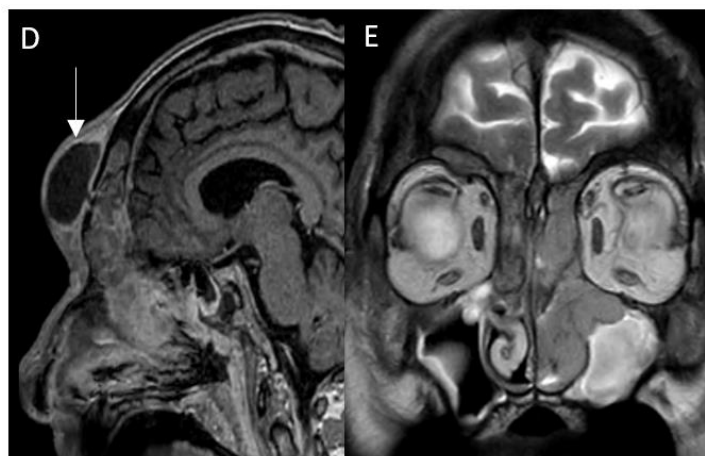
D. Contrast-enhanced MRI of the brain: fluid-like collection in the frontal subcutaneous region (arrow). E: rhinosinusual formation with heterogeneous contrast enhancement
